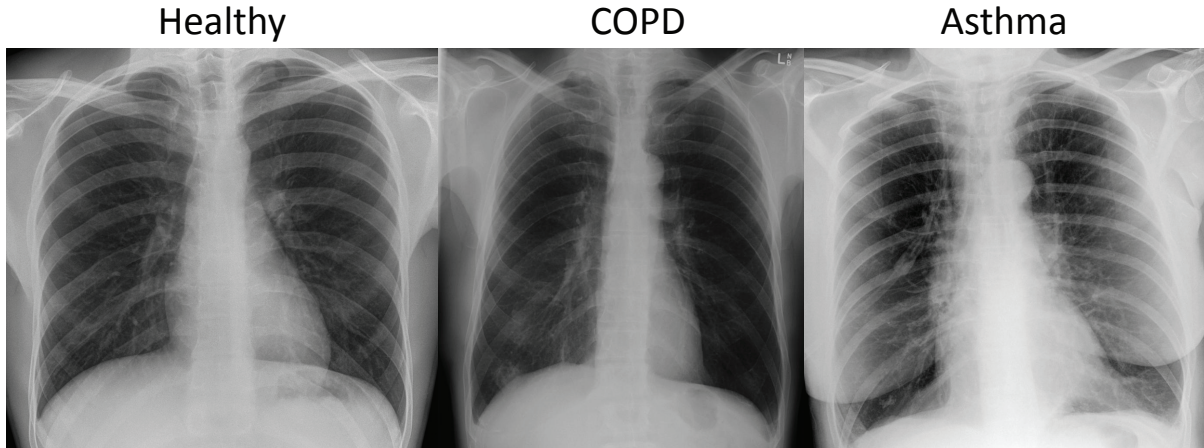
X-ray radiograph of a healthy, COPD and asthma subject. Healthy case courtesy of Dr. Ian Bickle, Radiopaedia.org, rID: 50318. COPD (predominantly emphysema) case from The Townsville Hospital, Radiopaedia.org, rID: 19446. The lung is hyper-inflated as evidenced by more than 10 posterior ribs, flattened diaphragm, narrowed mediastinum and regions of hyper-lucency that are indicative of emphysema. Asthma case courtesy of Dr. Ian Bickle, Radiopaedia.org, rID: 33470. Lung hyper-inflation is indicated by flattened diaphragm and more than 6 anterior or 10 posterior ribs at the lung diaphragm level.
